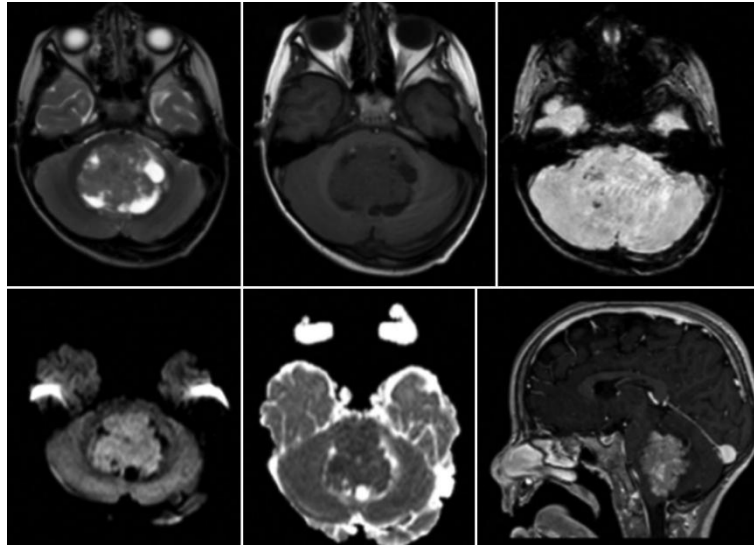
Predominantly solid expansive lesion with cystic/necrotic areas in the dilated fourth ventricle, with a mass effect on the periventricular cerebellar parenchyma, ventral displacement and compression of the brainstem, and collapse of the peritricuncular cisterns. It exhibits iso-hypointense signal on T1 (A) and T2 (B) images, with restriction on DWI sequences (D and E), and punctate hypointense images on SWI (C), which may correspond to calcifications. Post-contrast T1-weighted sequence (F) with heterogeneous enhancement
